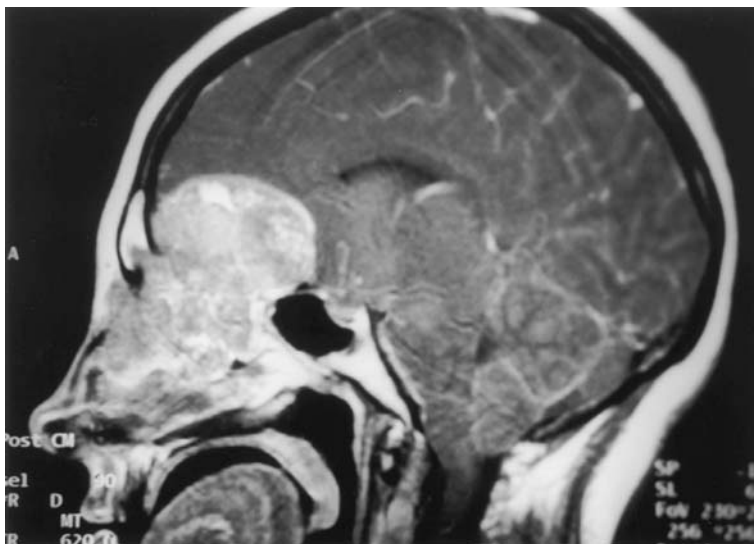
Sagittal MRI of patient with large olfactory neuroblastoma.
